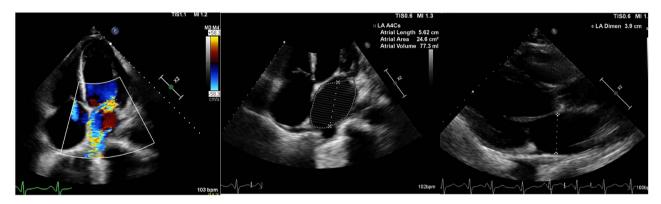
Transthoracic Echocardiogram. (A) Colour doppler four chamber apical view demonstrating severe mitral regurgitation and dilated right atrium and ventricle. (B) Four chamber apical view showing evidence of left atrial dilatation. (C) Parasternal long axis view demonstrating increased left atrium length, and right ventricular dilatation.
